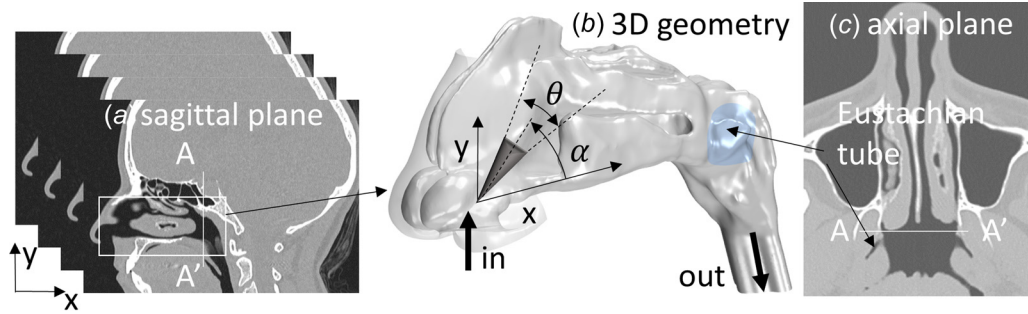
Reconstruction of the model's control volume geometry based on the CT scans from subject 1. (a) Stack of sagittal planes where the red frame highlights the model's geometry region. (b) three-dimensional control volume with inlet and outlet boundary conditions annotated with black arrows. The spray cone injector is annotated with a dark gray triangle. The shaded gray area marks the surface used for counting particles depositing on the ET. (c) Axial image indicating the location of the ET opening. AA' is a plane located just upstream of the entrance to the ET and is used for assessing the count of particles that can be deposited into the ET.
